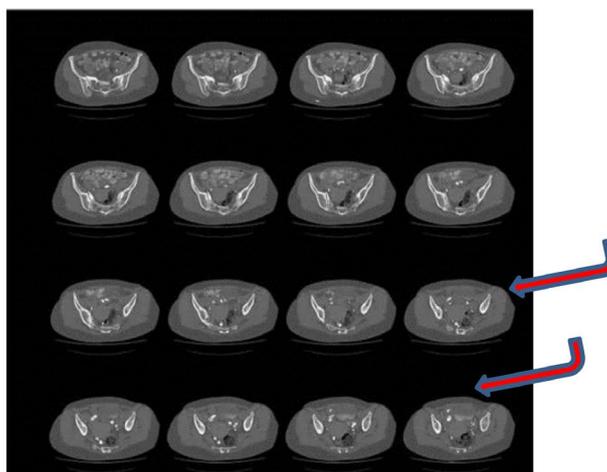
CT scans show multiple calcifications in the abdomen and pelvis.
